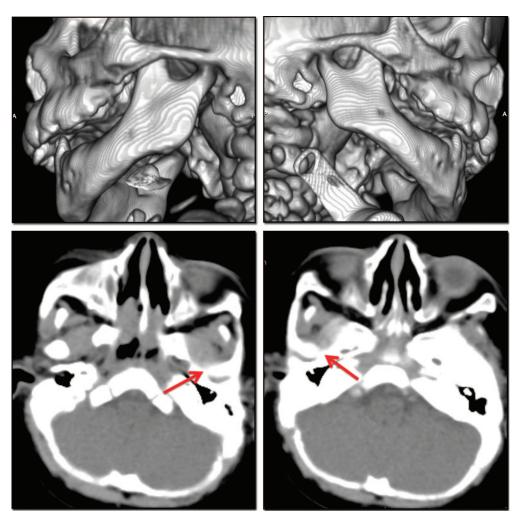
Case 3. Two- and three-dimensional reconstructed computed tomographic scans of a female infant (patient 5) with congenital (bilateral) temporomandibular joint ankyloses. *Arrows* indicate the sites of the ankyloses.
